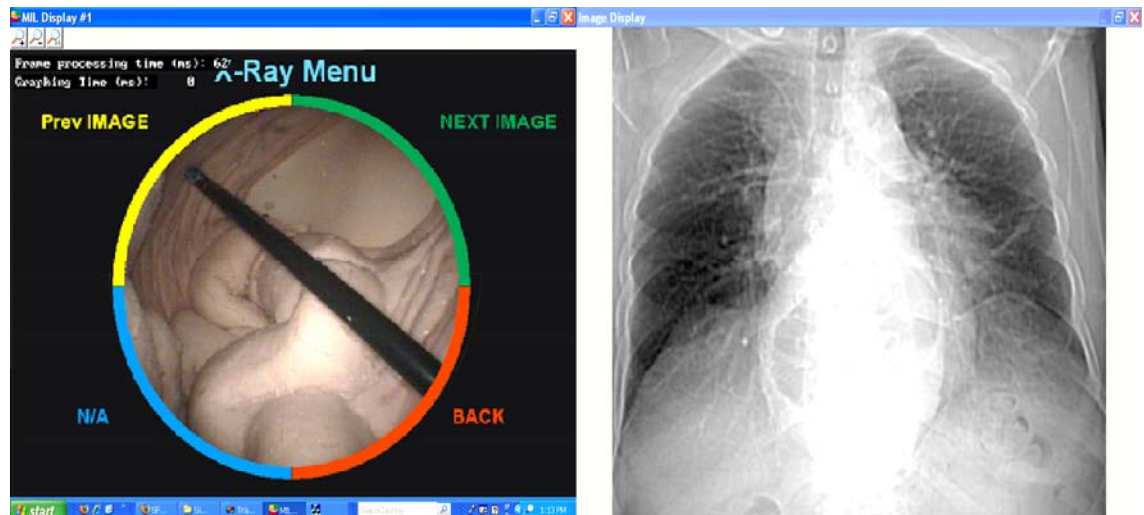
In X-Ray menu, user can choose previous or next image or go back to the main menu
